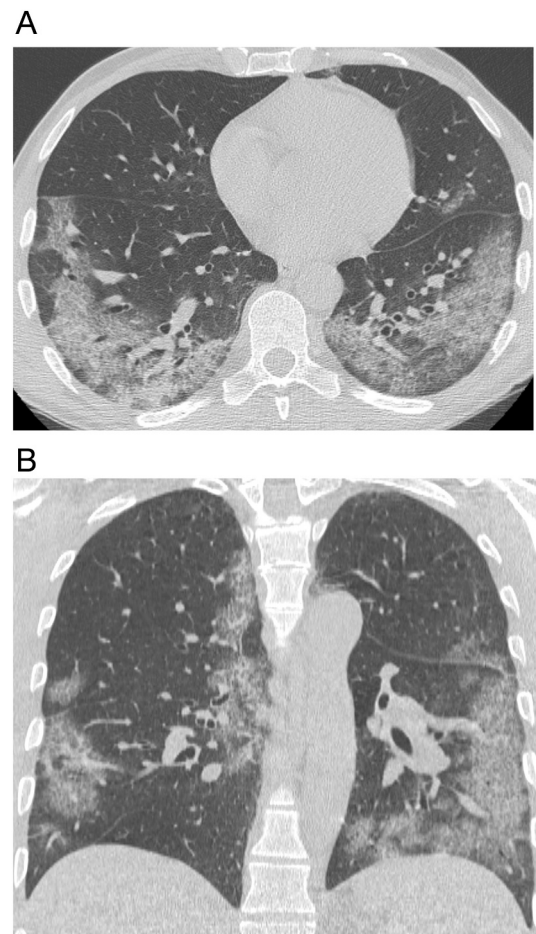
56-year-old man with confirmed severe acute respiratory syndrome coronavirus 2 disease (COVID-19) pneumonia and no comorbidities. High-resolution computed tomography (HRCT) was performed on day of hospital admission.
